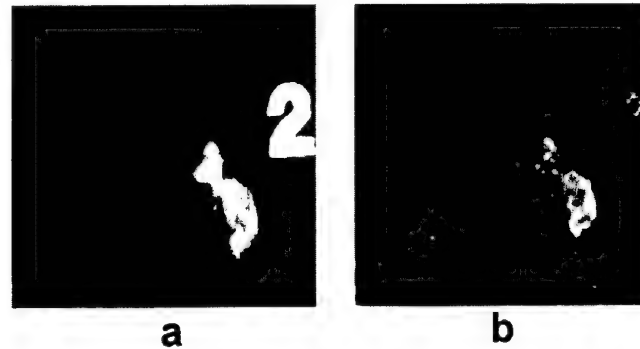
Vibro-acoustography of excised human carotid arteries: (a) x-ray image showing a normal (left) and a calcified (right) artery placed on a sheet of latex; (b) vibro-acoustography of the arteries in (a) measurement at a vibration frequency of 7 kHz. The calcification is seen as a bright region in both x-ray and vibro-acoustography images. Lead number '2' is used for identification.
